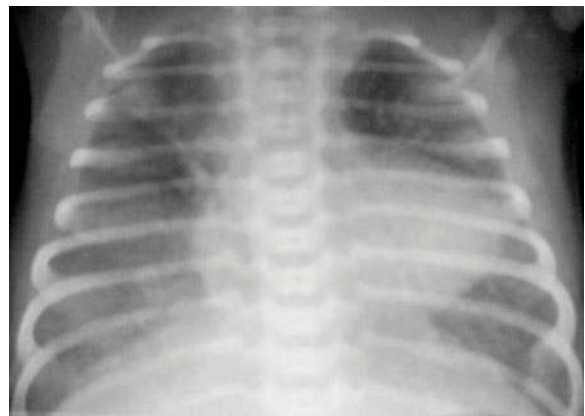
A 1-day-old boy with pulmonary atresia and a large ventricular septal defect (VSD). Chest radiograph shows elevated apex and concave contour at the level of the pulmonary artery. The pulmonary arteries turned out to be missing completely, and three MAPCAs were going from the descending aorta to the right lung and one to the left. The patient was operated with unifocalization of the MAPCAs. These arteries were fed from the aorta through a 4-mm central Gore-Tex shunt
